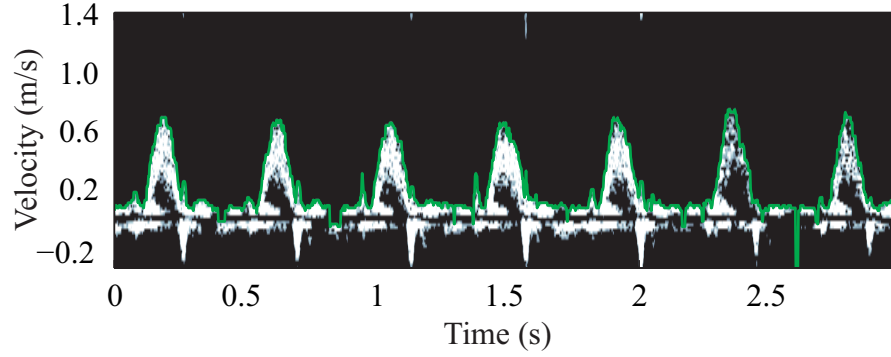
The Doppler spectrum of the LVOT flow velocity: the envelope of the spectrum was traced automatically.
